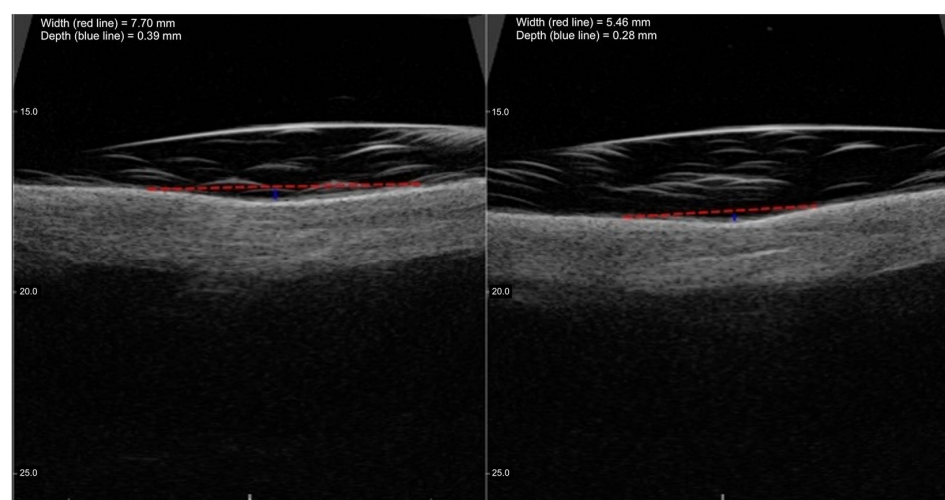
Representative high-frequency ultrasound images showing the reduction in SD width and depth before and after 1470 nm non-ablative laser therapy. The left panel shows baseline evaluation, while the right panel corresponds to Day 118–132 post-treatment. A marked decrease in lesion depth and dermal indentation is visible, consistent with progressive tissue remodeling and clinical improvement. The blue line and the red line indicate the width and the depth of the SD lesion, respectively.
